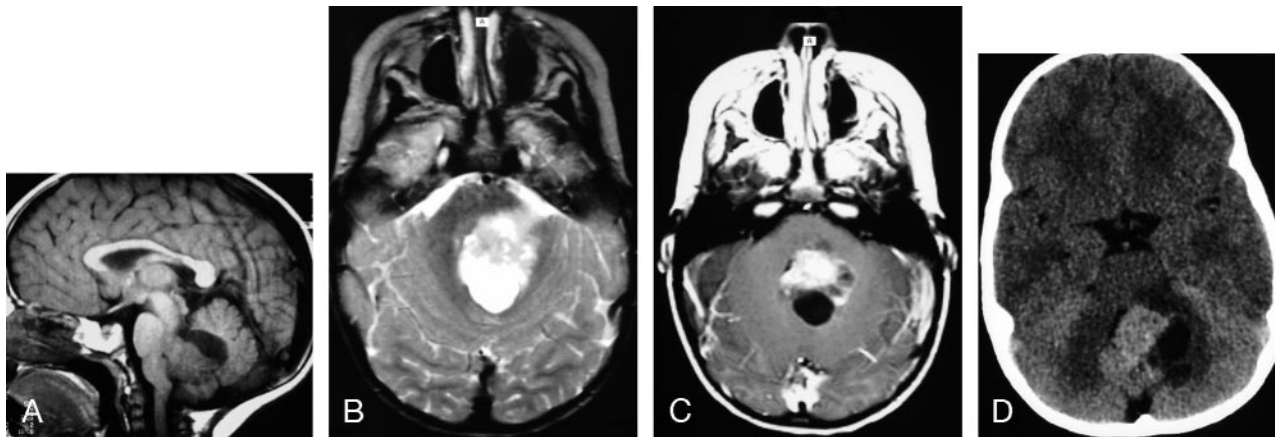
MR images of a 2-year-old girl with a germ-line mutation of the hSNF5/INI1 gene and AT/RT in the vermis extending into the fourth ventricle.
